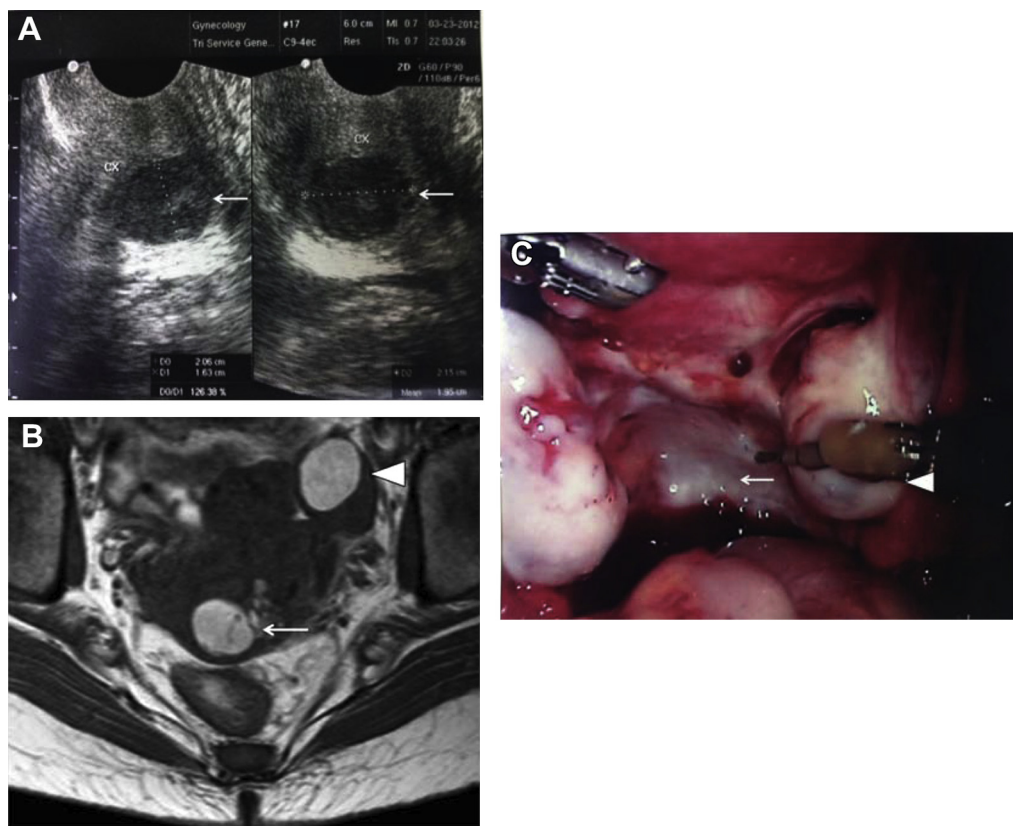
(A) Transvaginal sonogram of an endometrioma deep in the cervical stroma (arrow). (B) Magnetic resonance image of cervical endometriosis (arrow) and the endometrioma of the left ovary (arrowhead). The cervical tumor was on the sigmoid colon. (C) Pelvic view during the operation: cervical endometriosis prior to incision (arrow; as in A and B) as well as the endometrioma of the left ovary (arrowhead; as presented in B).
